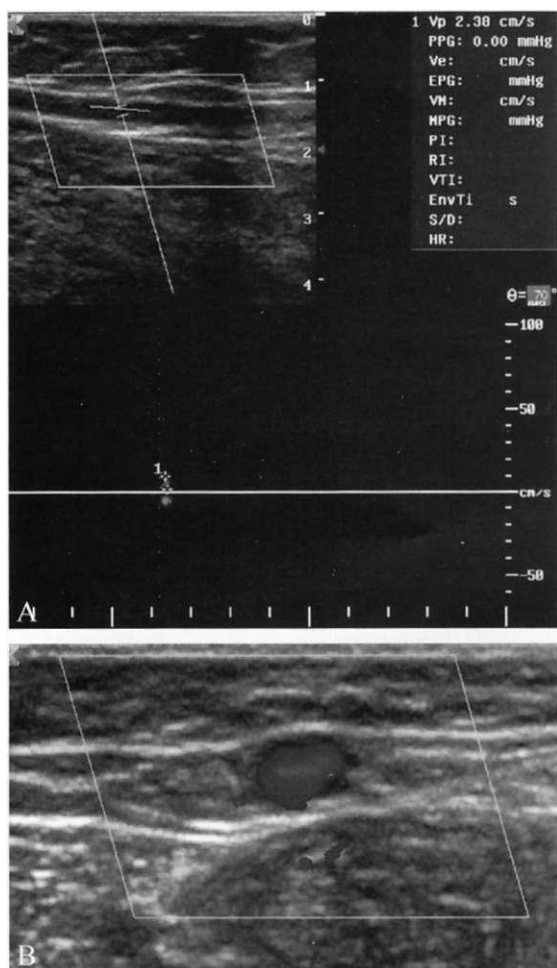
Doppler ultrasonography (A) and scan in the transverse (B) projection of the right GSV in the lower third of the thigh at 9 a.m. after the proper night's rest. The diameter of GSV in the problem area was 5.5 mm on the right side, and no reflux throughout the GSV was observed.
